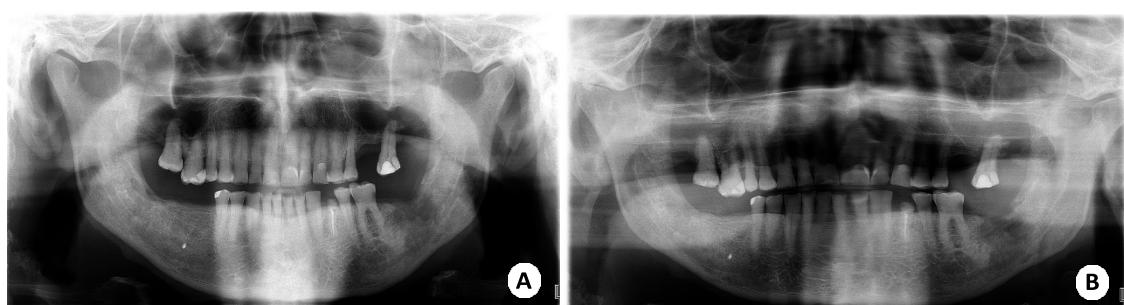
(A) Initial panoramic radiograph at baseline before tooth extraction; (B) Final panoramic radiograph within 90 days of starting treatment of ORN lesions with i-PRF.
